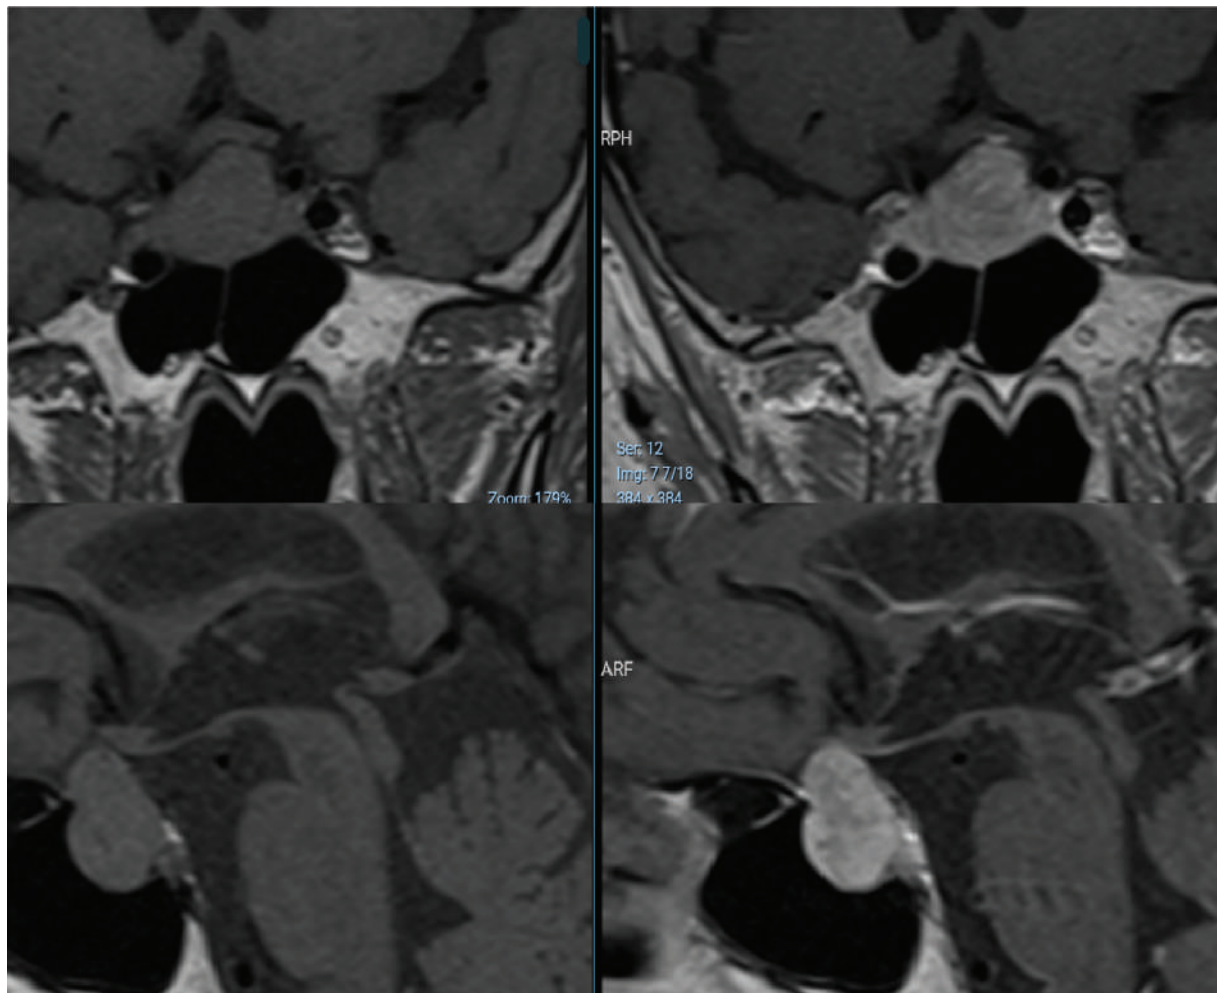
MRI 2 months after initial imaging revealing growth of the tumor. Sagittal sections disposed inferiorly and coronal superiorly, in noncontrast T1 weighted images on the left and postcontrast on the right. It is noted higher contrast enhancement and growth of the lesion toward the suprasellar compartment with optic chiasm compression. Also, there is expansion bilaterally with greater involvement of the right cavernous sinus and extension to the left internal carotid artery. The mass grew from 2.0 cm³ to 3.1 cm³.
